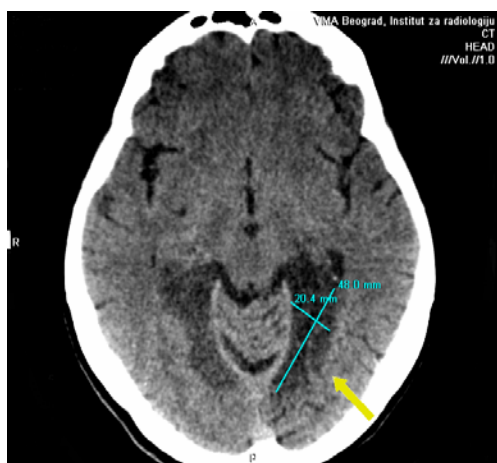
Axial noncontrast multislice computed tomography (MSCT) brain scan: bilateral areas of hypodensity in the hippocampus and parahippocampal gyrus demonstrate ischemic lesions. Left in the chronic, right in the subacute phase.
